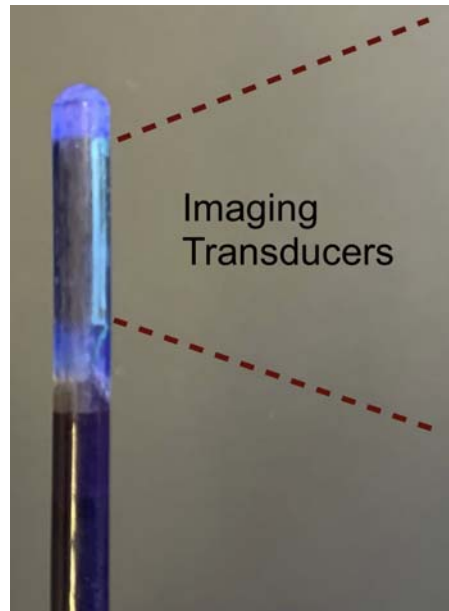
The tip of an intracardiac echocardiography imaging catheter. The transducer array is radioopaque and lines up along the end of the catheter to generate an image with the field of view vertical in the same axis as the catheter.
